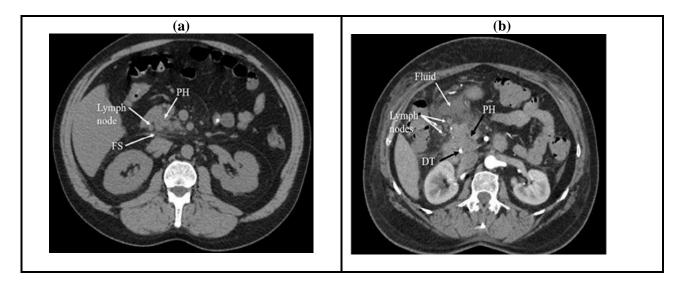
(a) Early stage of AP characterised by one swollen lymph node with stranding of surrounding fat (FS); (b) Pancreatic head inflammation accompanied by many enlarged lymph nodes and surrounding fluid (The arterial phase of CT, PH: pancreatic head, DT: duodenal tube). (27)
